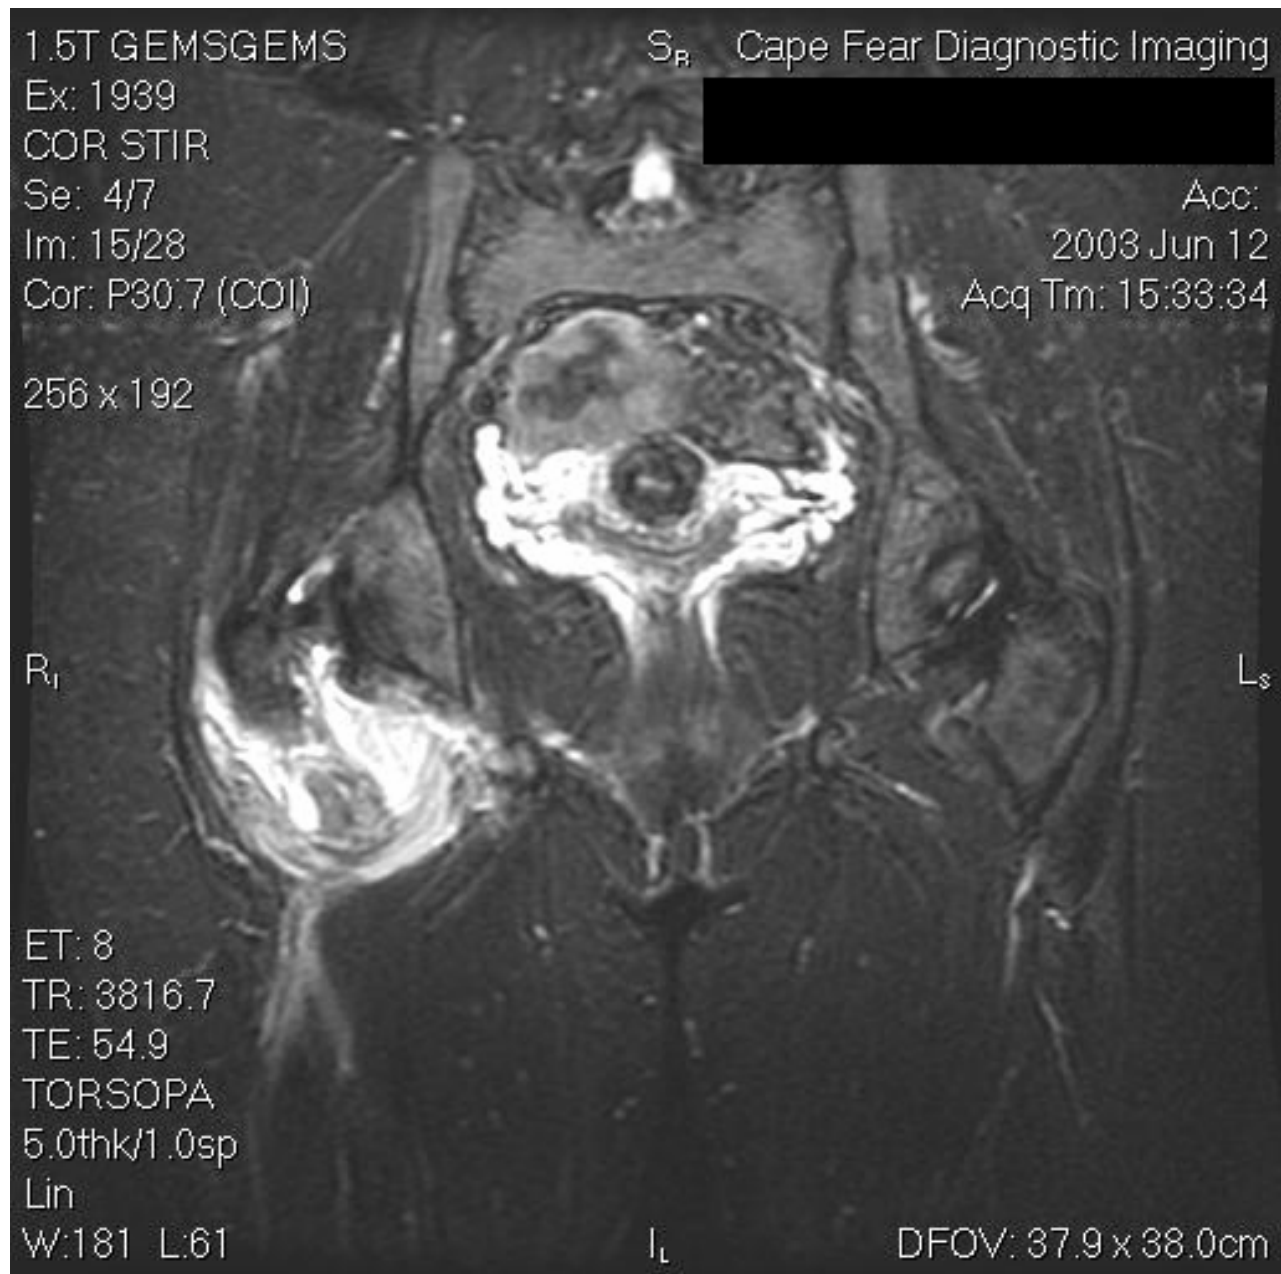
MRI - Coronal STIR Image – Pelvis – Increased signal consistent with deep gluteal hemorrhage due to Coumadin induced coagulopathy.
